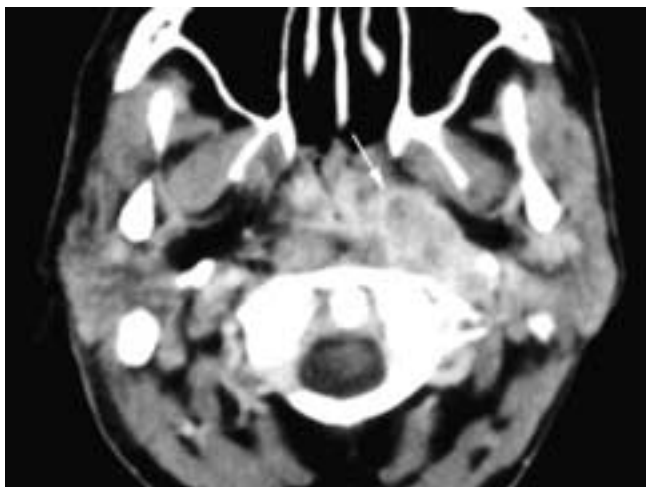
Axial contrast-enhanced CT scan shows an abscessed left retropharyngeal node (*arrow*) with an enhancing nodal capsule in a patient with an acute bacterial pharyngitis. Note that only the node and not the entire retropharyngeal space is enhancing, a differentiating point from a retropharyngeal abscess.
